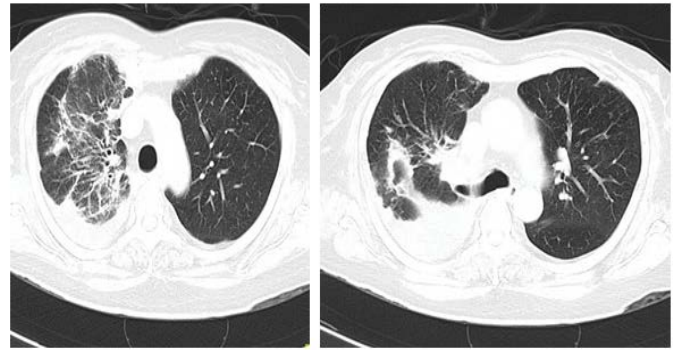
a & b – CT chest on Day 9 – Right sided resolving pneumonia with ground glass opacity.
